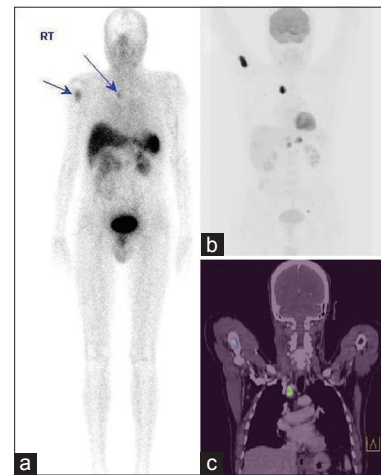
Whole-body Hynic-TOC anterior image (a) showing moderate uptake in the recurrence in the thyroid bed and cervical nodes, whole-body fluorodeoxyglucose-positron emission tomography/computed tomography (CT) maximum intensity projection image (b) intense uptake in the right neck nodes. Fused Hynic-TOC single-photon emission computed tomography/CT (c) uptake in the right level II cervical nodes and thyroid bed
